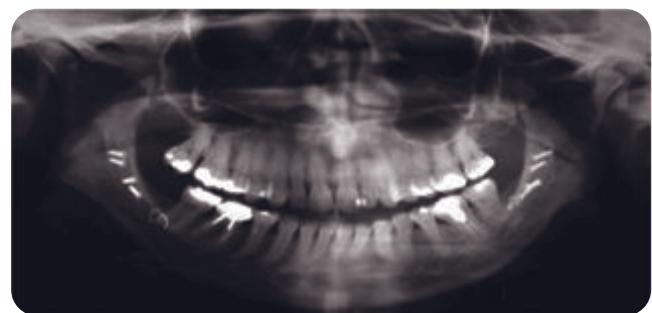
Pretreatment panoramic radiograph suggesting significant remodeling and asymmetry in the left condyle.
